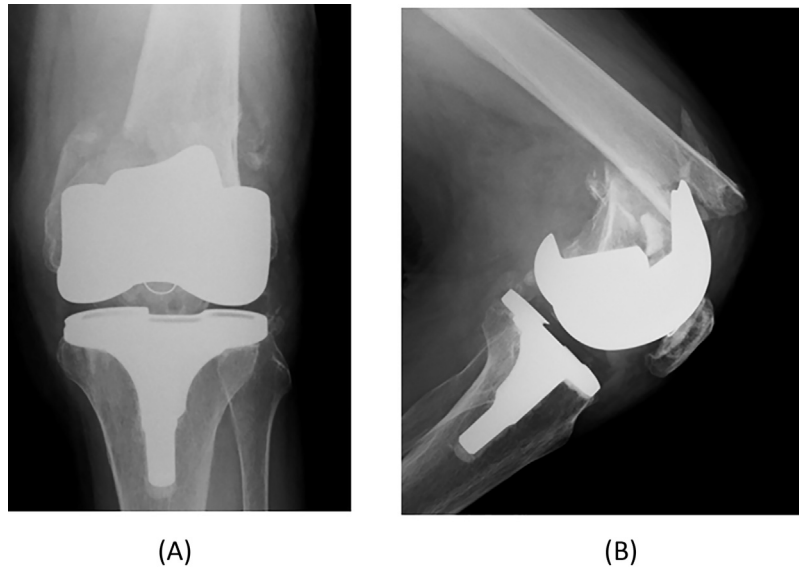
(A) Frontal and (B) lateral radiographs of the knee at the time of the clinic visit.
